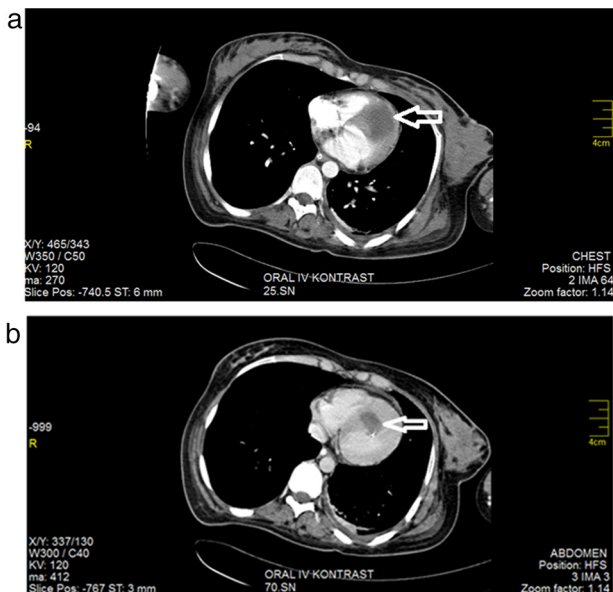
(a) Thoracic CT-scan view showing a hypodense cyst of the interventricular septum (arrow) and (b) thoracic CT-scan view showing partially calcified edges of cyst (arrow).
